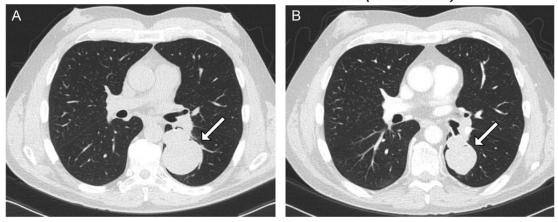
Patient MC3 was a 51-year-old male treated with lenvatinib as their ninth line of therapy. Previous therapies were as follows: EDP, gemcitabine, capecitabine, cyclophosphamide, mitotane, etoposide, docetaxel, and pembrolizumab. (A) Disease burden prior to starting lenvatinib. (B) The patient had a partial response of their lung metastasis on chest CT, shown here after 14 months of continuous lenvatinib. They went on to receive lenvatinib for another 6 months, for a total of 20.3 months, before discontinuing therapy and experiencing disease progression shortly thereafter at 23.5 months.
